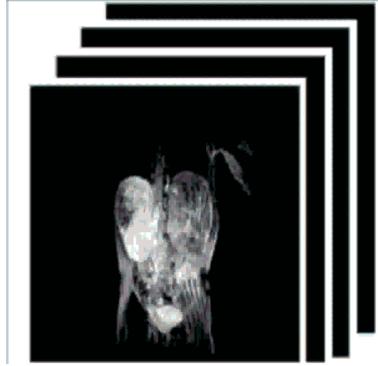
Data by using MRI[16]
